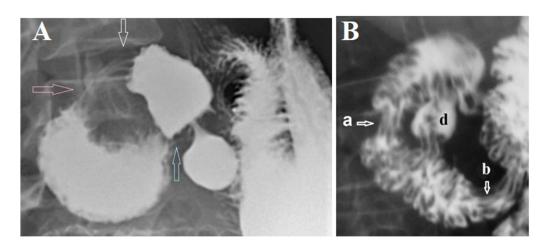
Radiographs of elderly patients with duodenitis and duodenal dyskinesia. (A) The duodenal bulb is expanded and deformed. Despite the large volume of contents, it continues to receive chyme, since the bulb has not reached its maximum capacity. This indicates a high tone of PBS (white arrow). A sharp expansion of the intestine is determined between the Kapanji sphincter (pink arrow) and the Ochsner sphincter (blue arrow). This expansion is due to the high pressure that occurs when both sphincters contract; (B) The duodenum was emptied, but the barium remained in deep folds because the barium-filled bowel was very wide. Two zones of contraction with longitudinal folds are visible: (a) the Kapanji sphincter, and (b) the Ochsner sphincter. The juxtapupillary diverticulum is located between them. These diverticula result from the extrusion of the mucosa between the muscular fibers. Thus, this diverticulum is evidence of high pressure that occurs during contraction between Kapanji and Ochsner sphincters [6].
